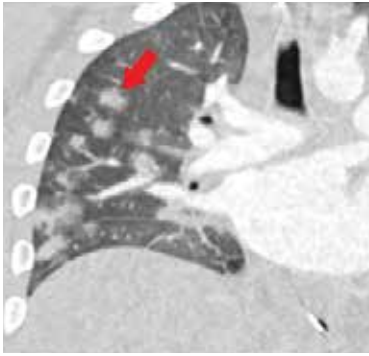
15-year-old male presenting with fever, sepsis, and shock with impaired cardiac function. Coronal reconstruction of a contrast-enhanced CT chest shows multiple round consolidative foci with surrounding ground glass halos (red arrow).
